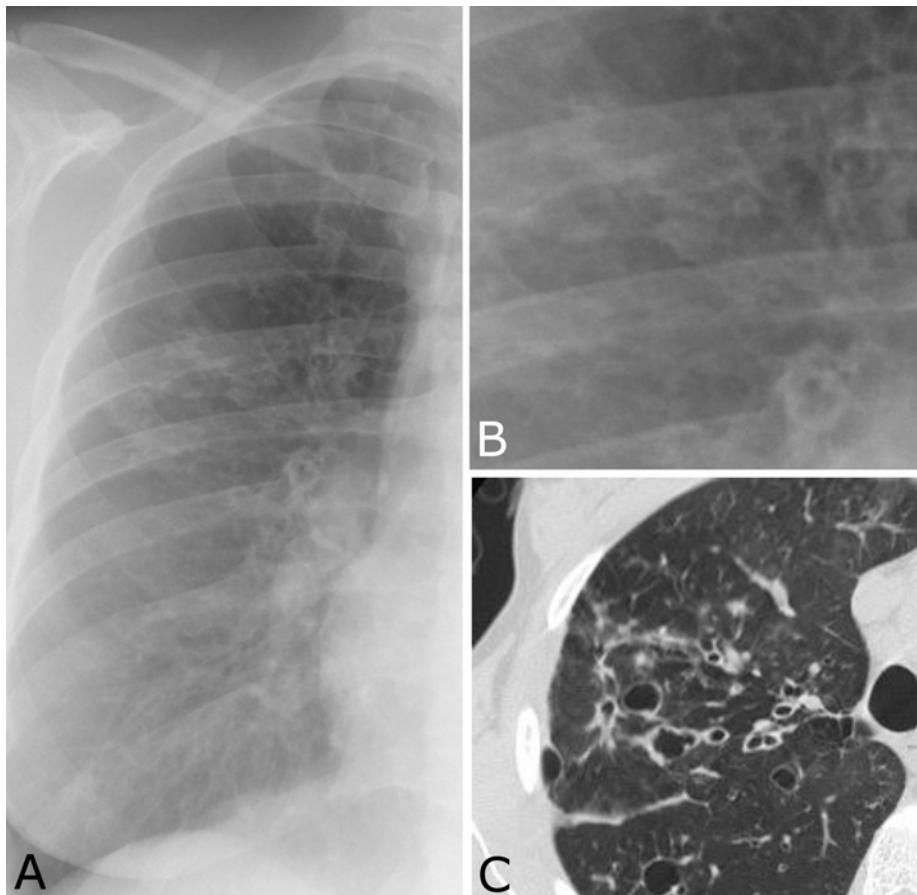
Bronchiectasis. A. Frontal radiograph of a patient with cystic fibrosis, a common cause of bronchiectasis. Notice the linear (interstitial pattern). B. Magnified view to show that many of the lines are actually circles (end-on, dilated airways). C. Axial CT image shows many of these circles throughout the lung.
